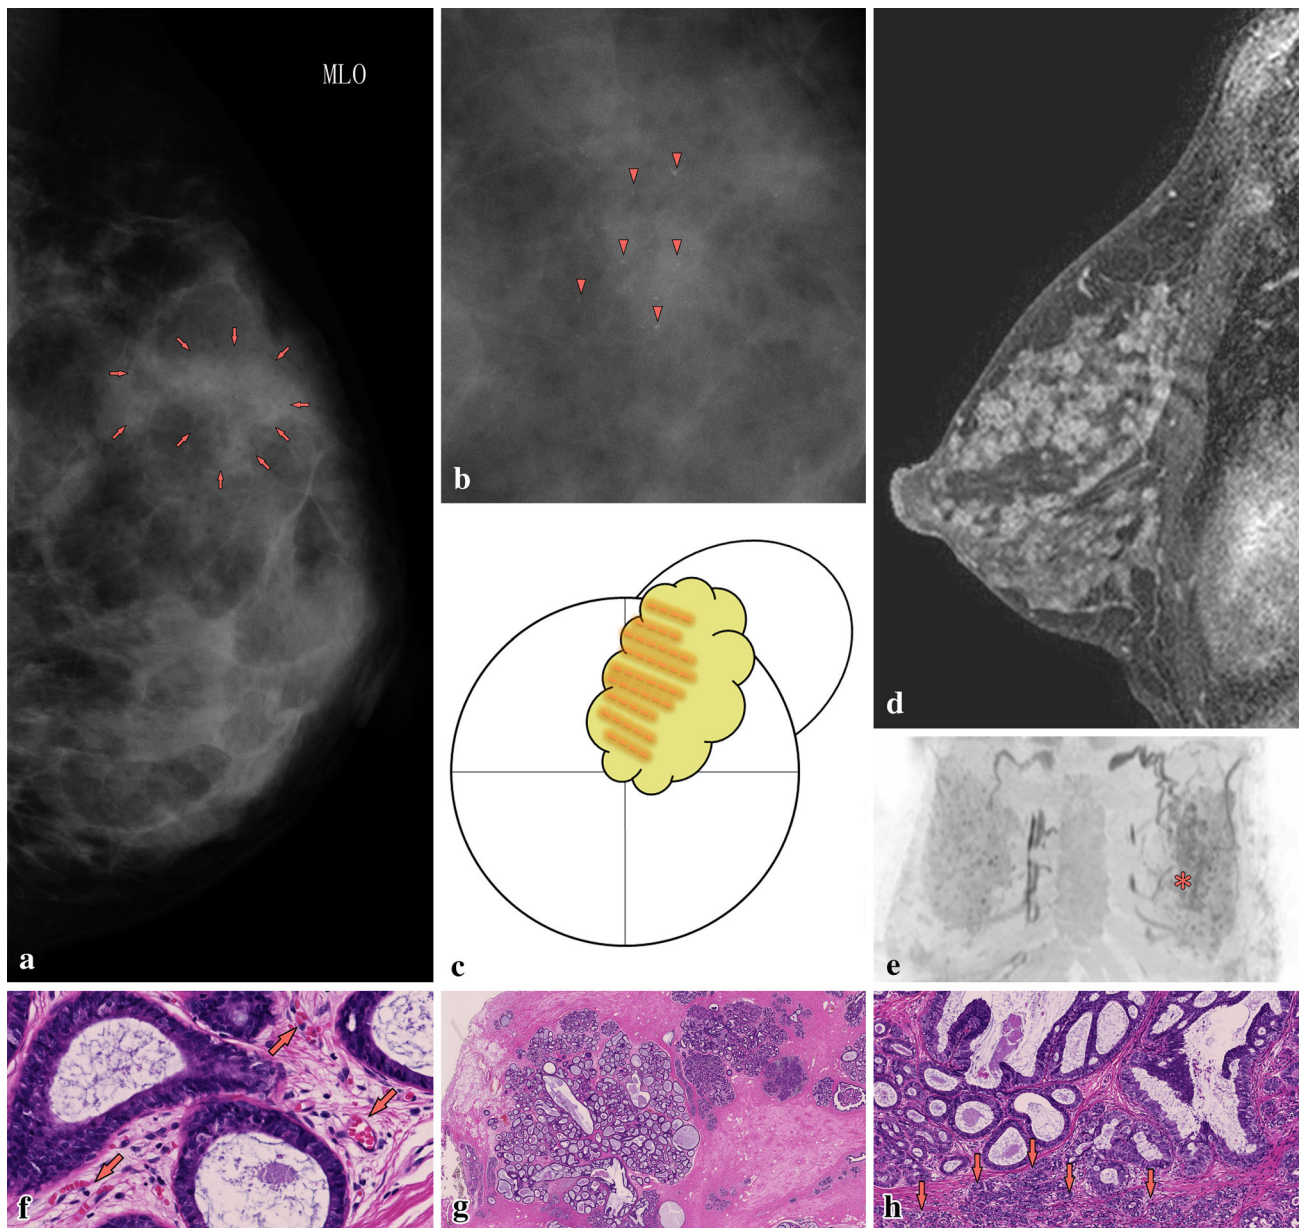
The case was a 42-year-old female with punctuate or amorphous microcalcifications on screening mammography [a, b, red arrow and red arrowhead, mediolateral oblique (MLO)]. MRI revealed periductal enhancement (clustered ring enhancement, horizontal plane), and DCIS was strongly suspected (d). DCIS was mapped on the partially resected breast sample (c, the orange line indicated DCIS), and the spreading area was matched to the MIP
